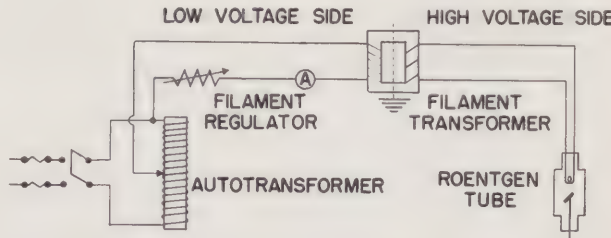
Filament circuit of a roentgen-ray machine.
